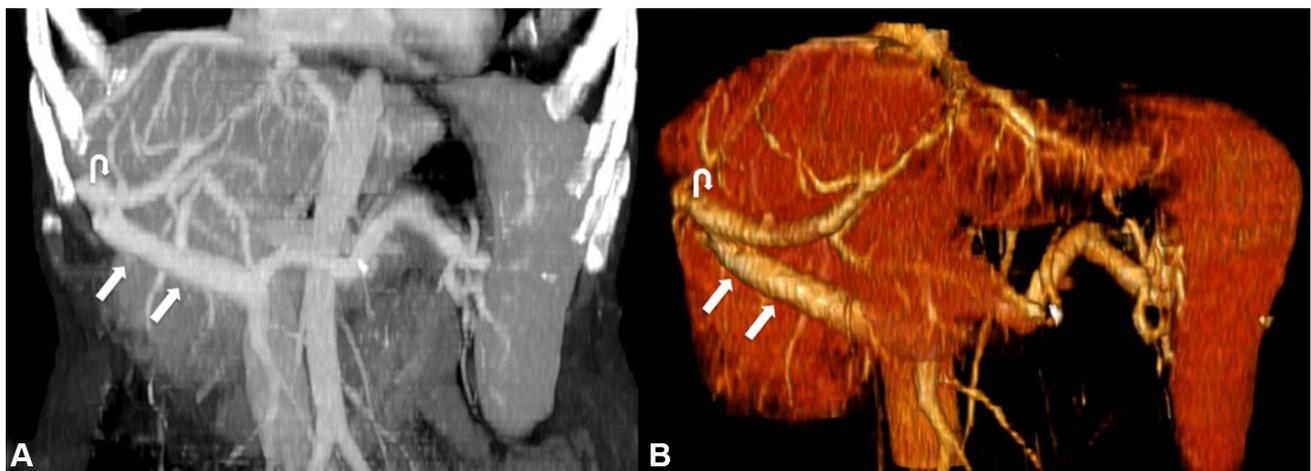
MIP (a) and VRT (b) reconstruction images from the venous phase of the CT study demonstrating the route of the portal vein on the outer side of the liver (straight arrows) and the origin of the RPPV (curved arrows)
